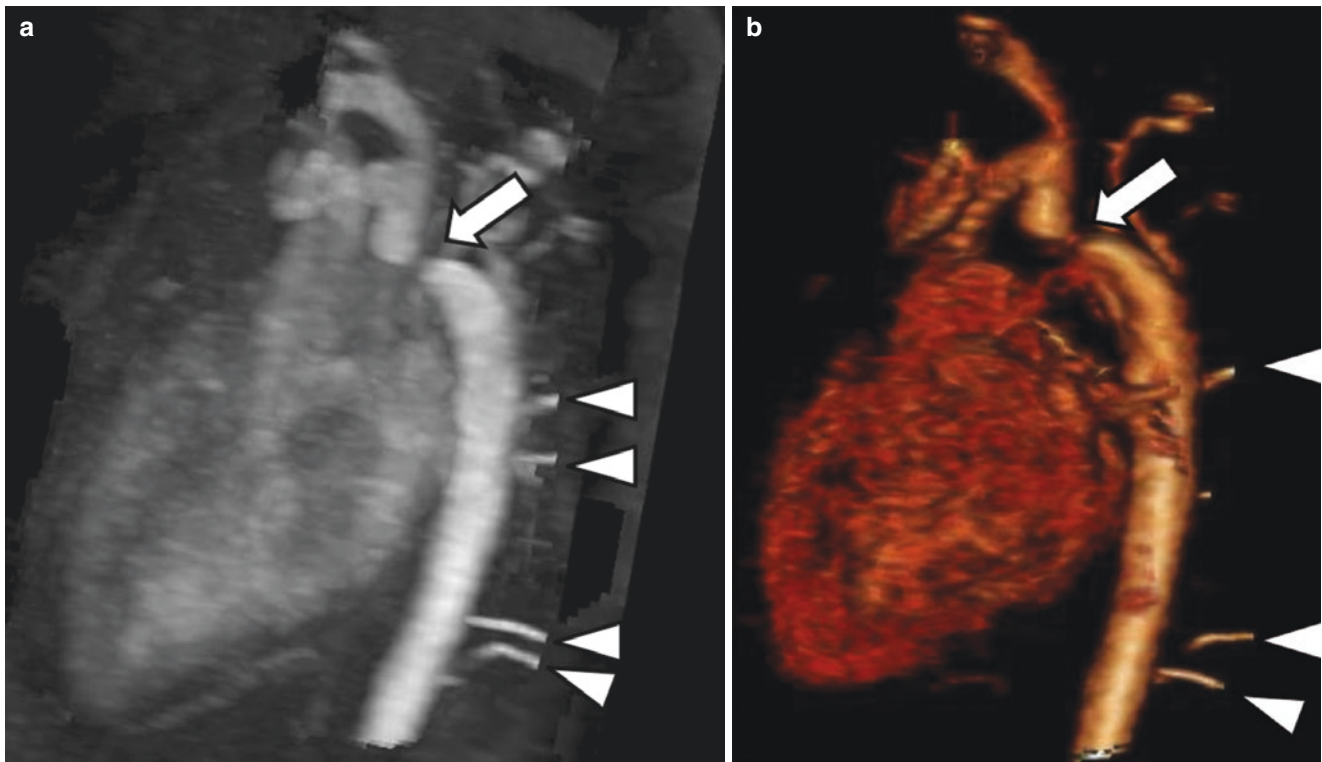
A 2-year-old girl with aortic coarctation. (a) Maximum intensity projection image from enhanced T1-weighted MR angiogram with fat suppression shows narrowing (arrow) of the aortic isthmus and multiple collateral arteries (arrowheads) arising from the descending
